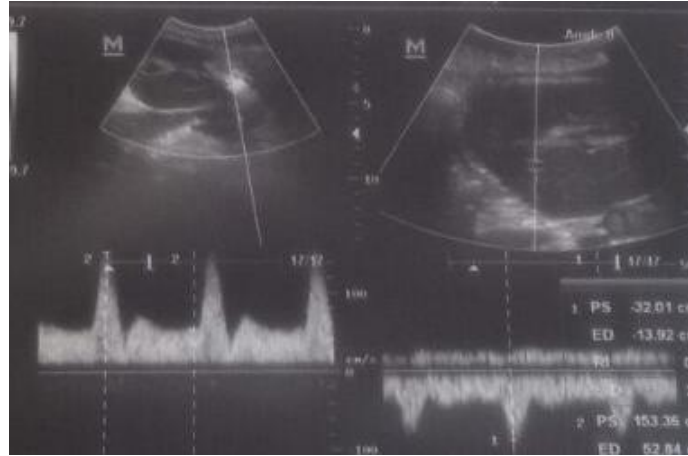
a sonogram shows spectral Doppler of a nephritic transplanted kidney
